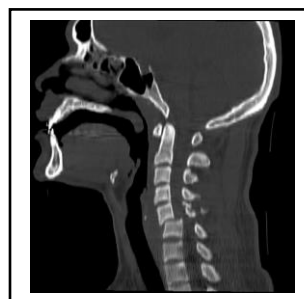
CT imaging showing comminuted C5 posterior element fracture with anterolisthesis of C5 over C6.
